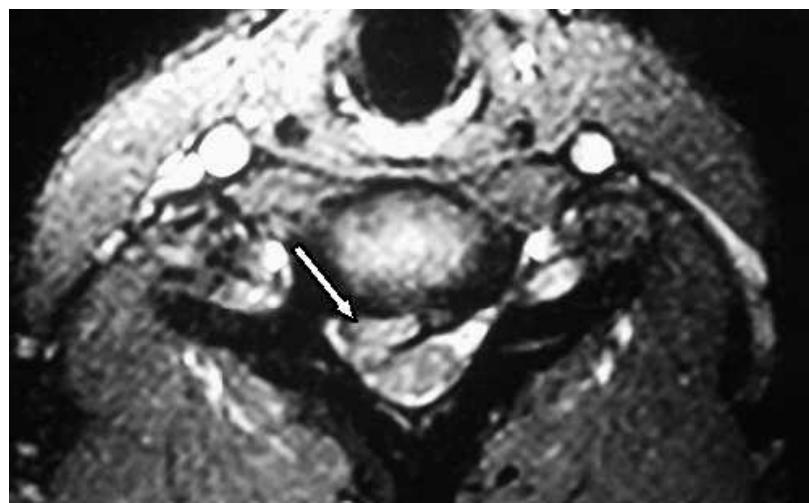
T2-weighted axial image showing a protruded nucleus pulposus and severe central compression of the ventral aspect of the cervical cord (the white arrow) in a 35-year-old female patient (No. 6).
